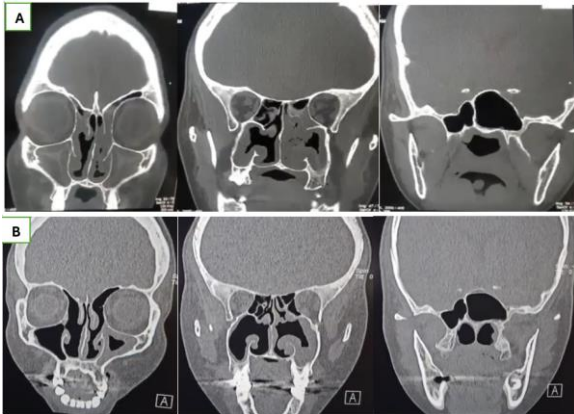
A: CT scan for a case with Lund Mackay score 20 before administration of dupilumab. B: CT scan for the same case with Lund Mackay score 4 after 6 months of administration of dupilumab
